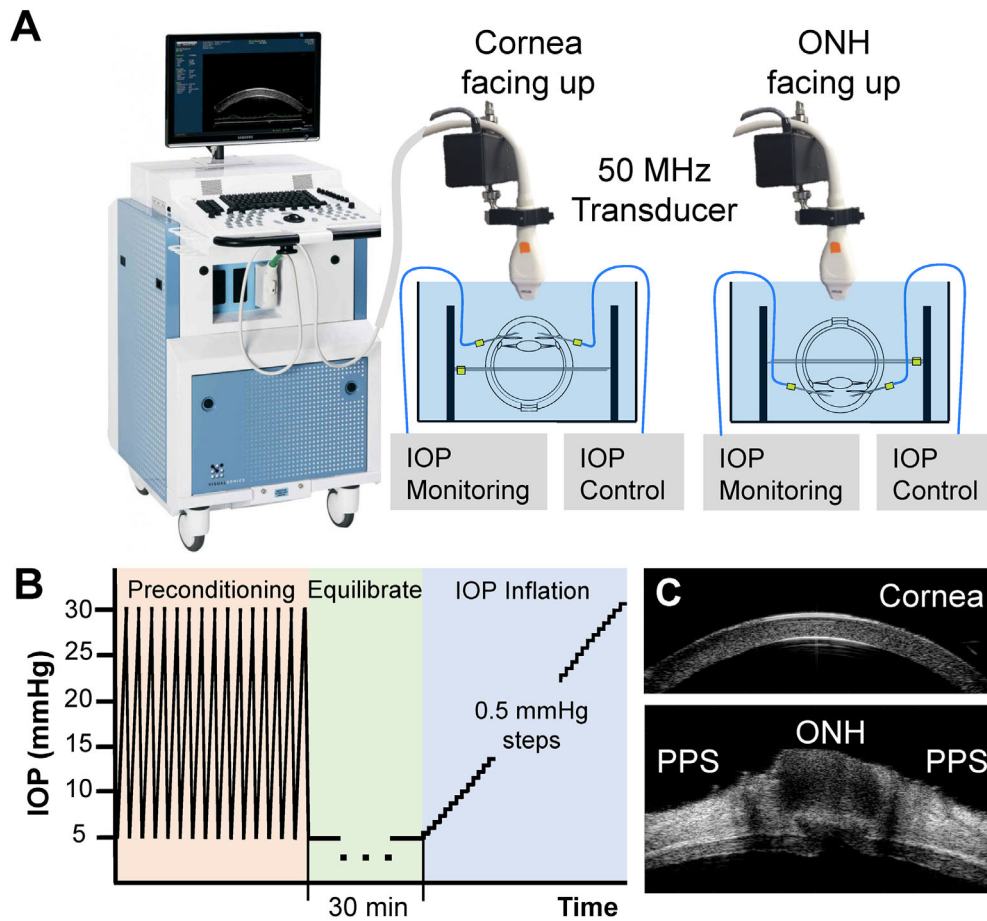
Experimental setup for inflation testing of human donor globes using high-frequency ultrasound elastography. (A) One eye of each pair of globes from the same donor was randomly assigned for corneal testing and the other for posterior eye testing. Globes were immersed in poloxamer/PBS (cornea testing) or PBS (posterior eye testing) with IOP control and monitoring. (B) Each eye went through the same testing protocol of preconditioning, equilibration, and inflation from 5 to 30 mmHg. (C) Representative ultrasound B-mode images of a cornea and a posterior eye.
